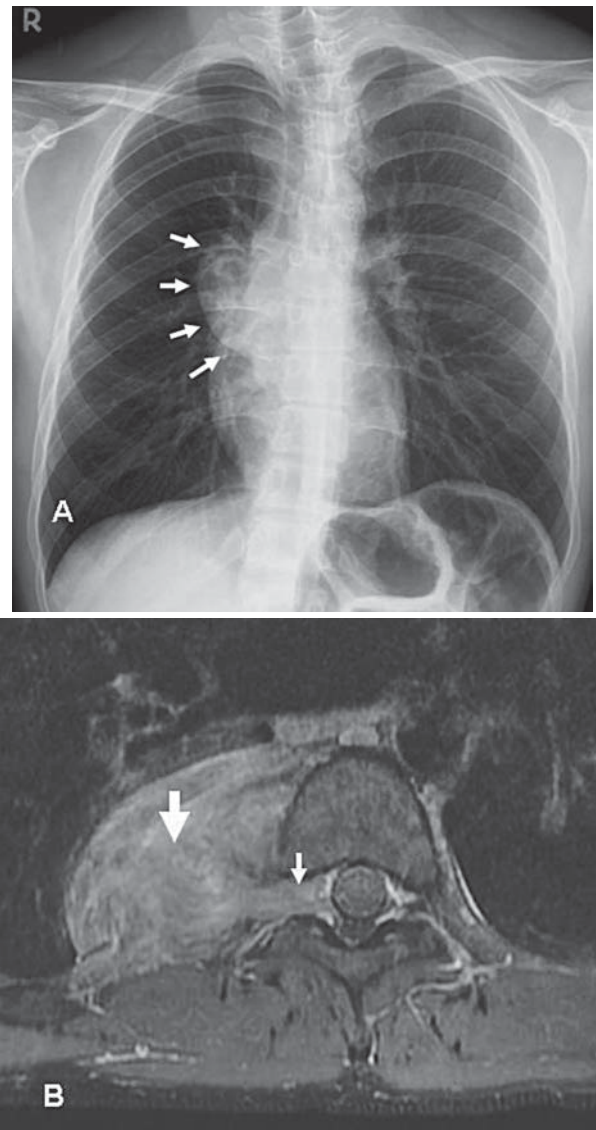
20 year-old man with an asymptomatic right paravertebral sulcus ganglioneuroma. A. Posteroanterior radiograph shows a large mediastinal tumor at the level of right hilum (arrows). B. MR imaging demonstrates narrow waist of tumor connecting large intrathoracic tumor (large arrow) with smaller intraspinal component (small arrow). The tumor shows heterogeneous signal intensity on T2-weighted image. Note enlargement of the neural foramen.
